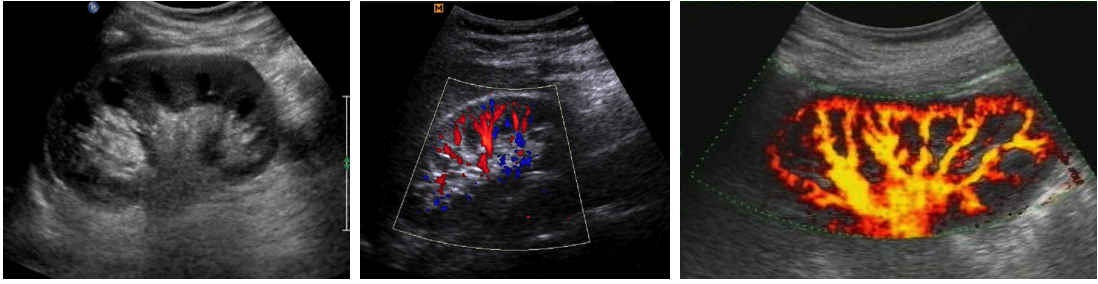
Examples of a B-Mode, Doppler and Power Doppler images of the kidney from different patients.
